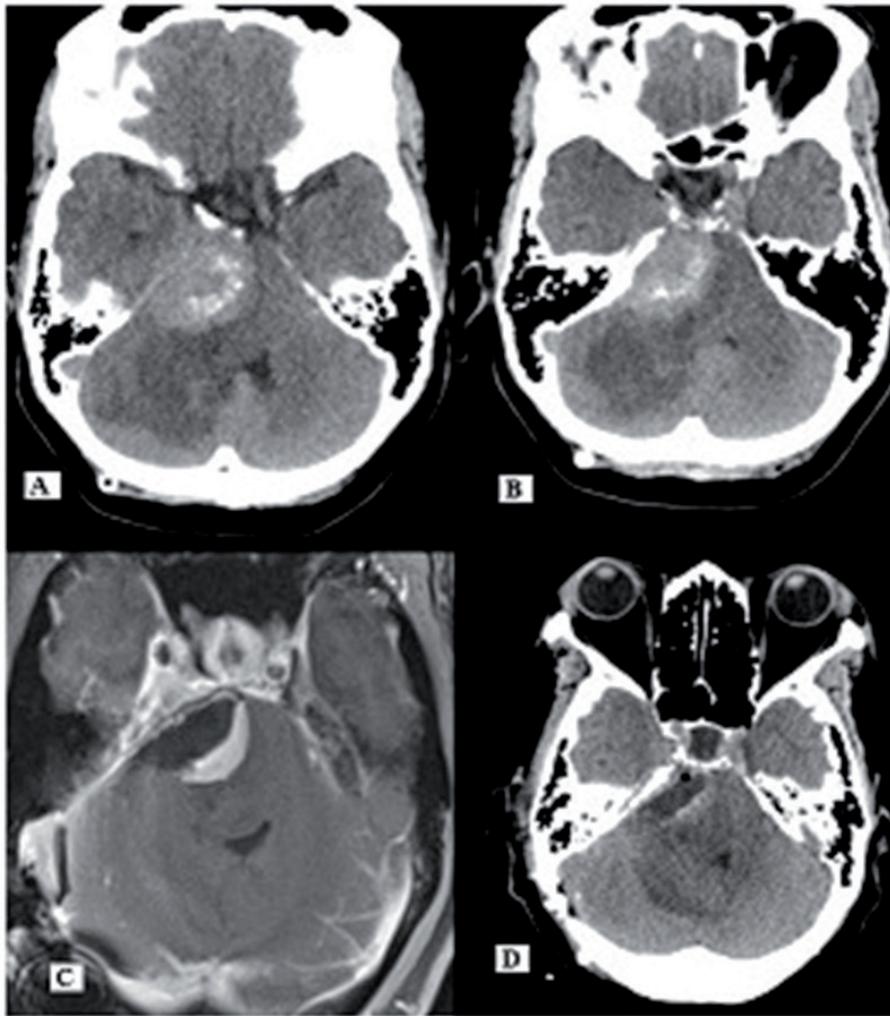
A&B preoperative CT image showing CP angle meningioma, C. ioMRI showing the residue along the brainstem which was difficult to mobilize hence it was left behind and size was less than 2 cm which was subjected for SRT, D post*-operative CT showing residue without any operative site hematoma. In this patient ioMRI helped to guide the surgeon to stop further resection and safely subjected for SRT without causing any neurological deficits.
